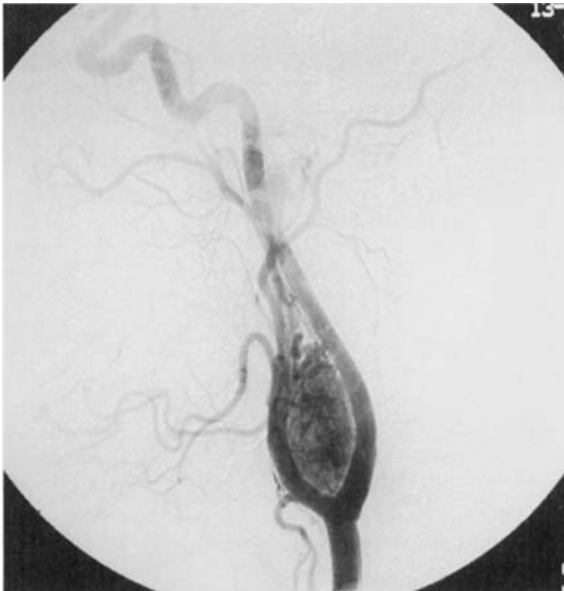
Paraganglioma. This carotid injection from a cerebral arteriogram reveals the characteristic hypervascularity associated with paragangliomas in this carotid body tumor situated at the carotid bifurcation. A small glomus jugulare, not apparent on this image, was present on the postcontrast CT scan. Paragangliomas are multiple in 15% to 20% of patients.
